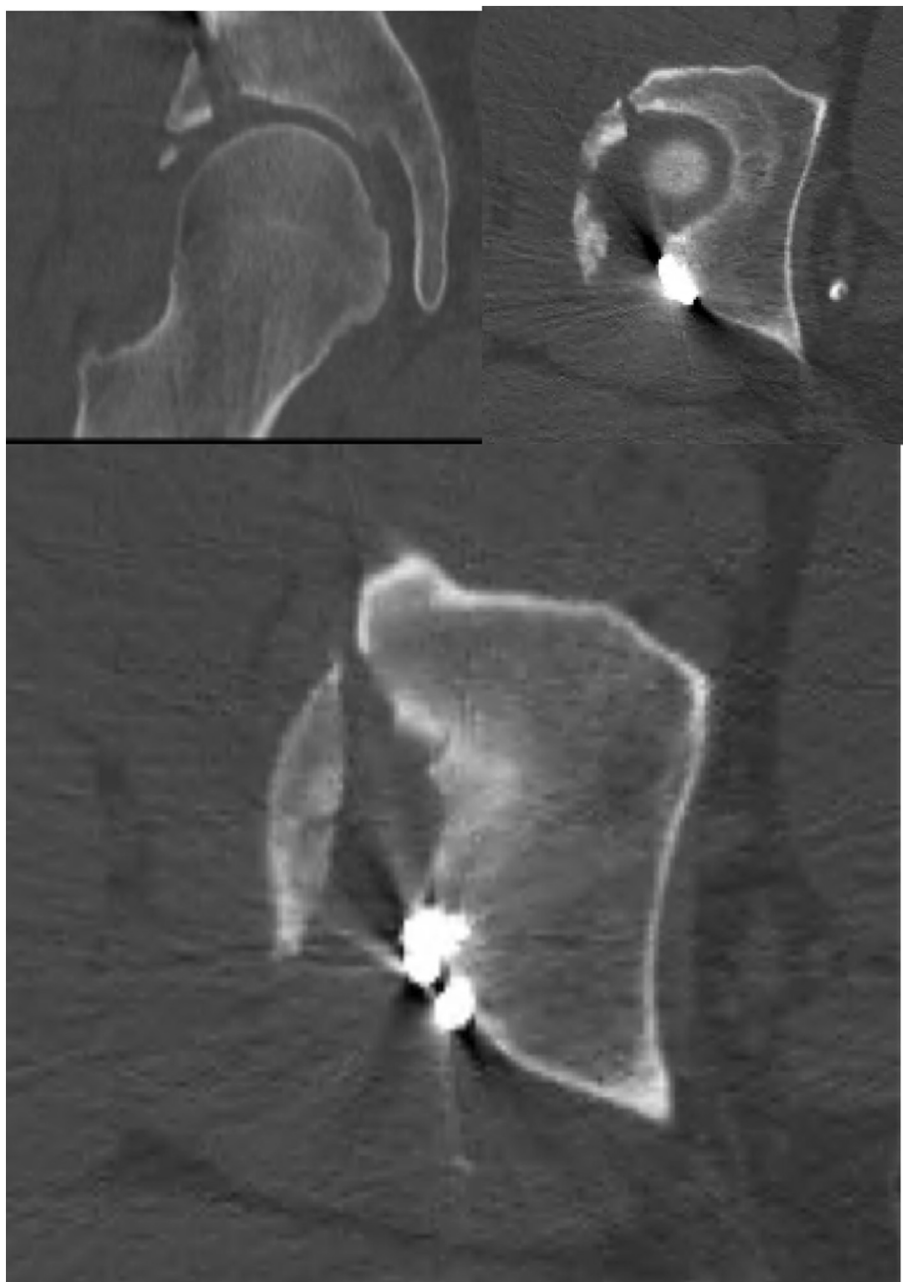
Key second injury axial and coronal CT pelvis images of the posterior wall fracture with evidence of initial posterior wall hardware.
